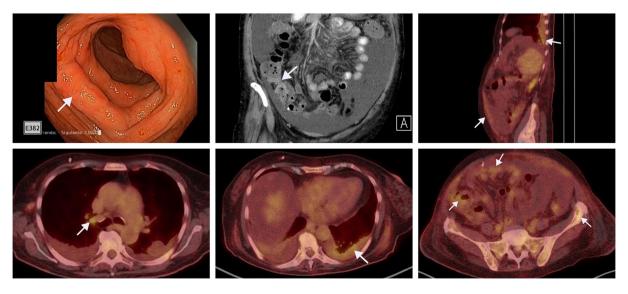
Endoscopic image revealing intestinal folds thickening in ileocecal valve region. Abdominal CT and positron emission tomography-CT showing cecum wall thickening and hypermetabolic activity in several areas.
